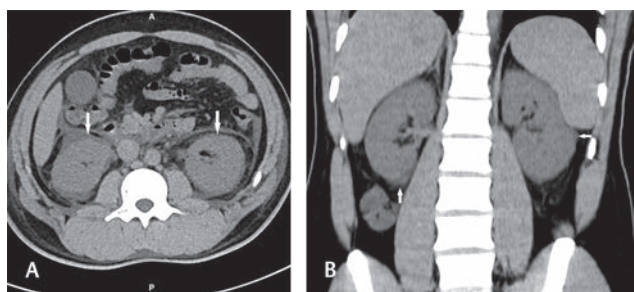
Axial (A) and coronal (B) noncontrast computed tomography abdomen images show bilateral enlarged kidneys with thin rim of perinephric fluid (white arrows) on both sides.
